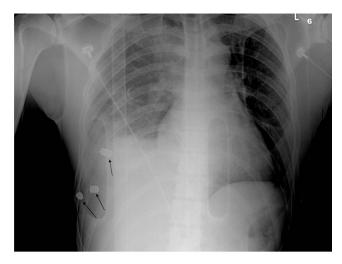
Chest X-ray depicting three foreign bodies in right thorax.
